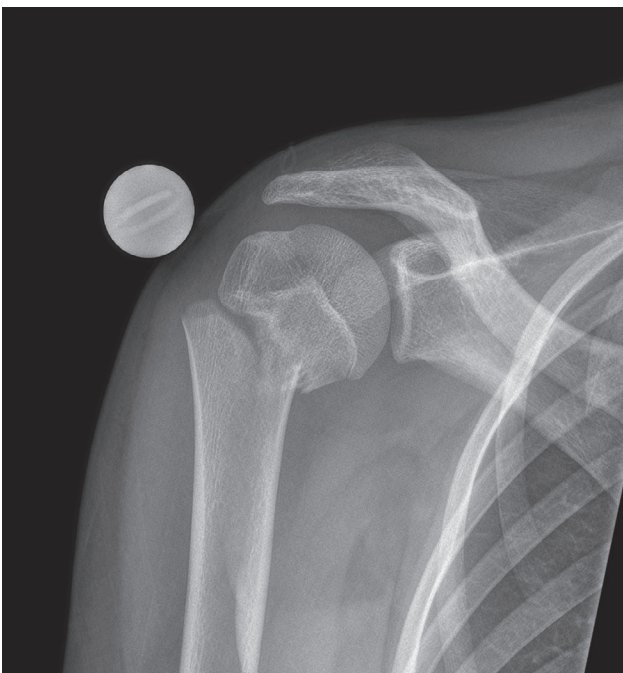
Antero-posterior X-ray of the right humerus, showing a displaced fracture of the proximal humerus.
